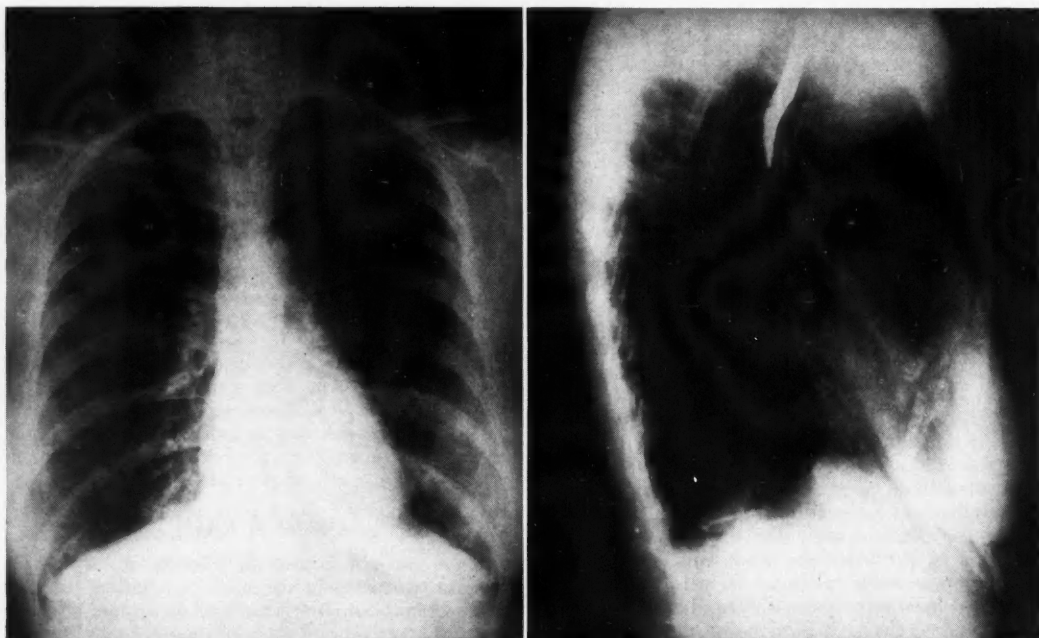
Left: Postero-anterior chest radiograph. Right: Lateral chest radiograph. No abnormalities of the mediastinum, heart shadow or lung fields are visible on the plain roentgenograms.
